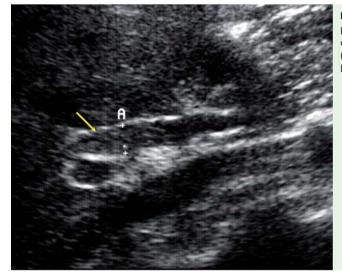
Ultrasonography showing an elliptical isoechoic mass (arrow) in the hilar left hepatic duct.
